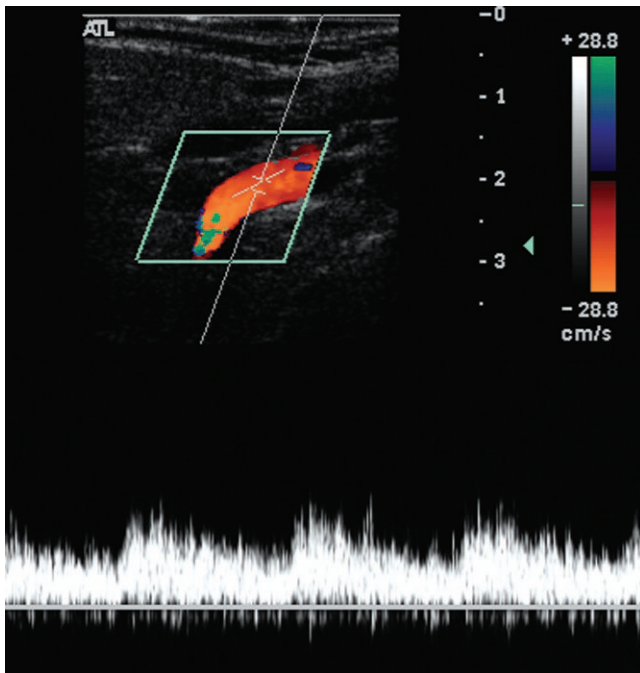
Abnormal spectral broadening. Spectral Doppler of the internal carotid artery downstream from a stenosis (not shown) has poststenotic turbulence and abnormal spectral broadening. The envelope is poorly defined and there are transient high velocity lines in the spectrum. All velocities are represented and there is filling in of the window. The velocities at the edge are less white and more gray than the lower velocities below peak, which are more white. This indicates slower, rather than faster, flow is more common. Fewer red blood cells are moving at the highest velocities. There is also simultaneous forward and reverse flow with signals above and below the baseline.
